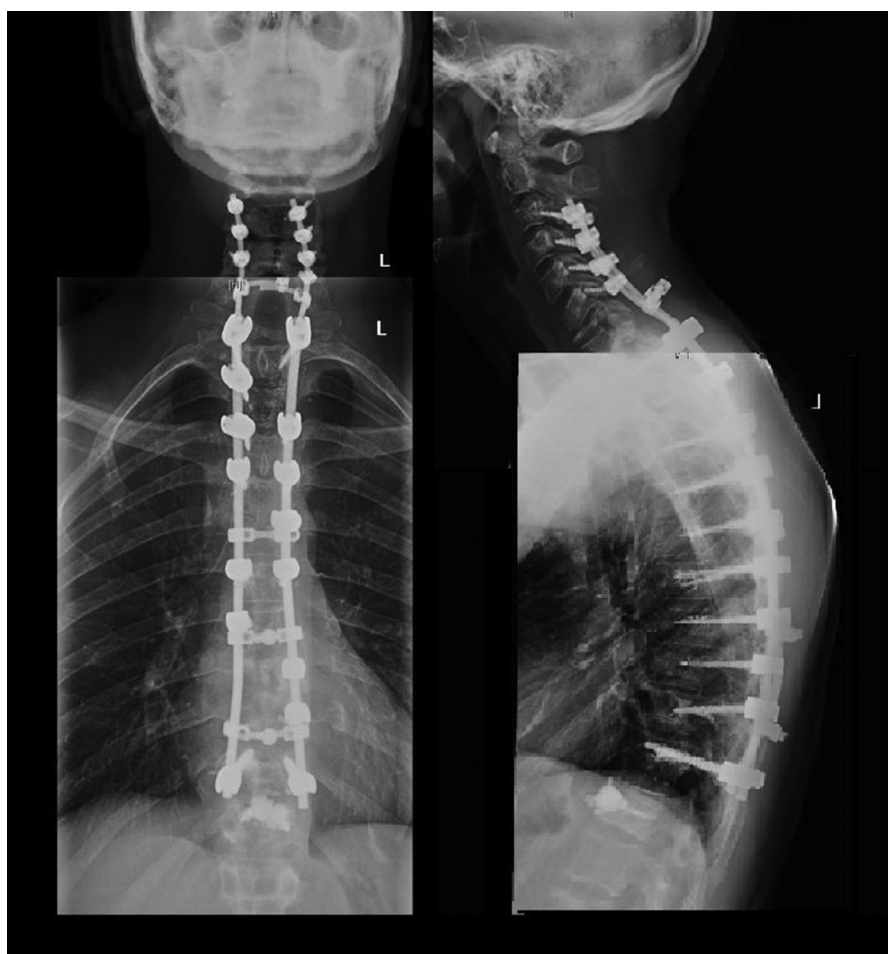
Postoperative coronal (Left) and sagittal (Right) X-rays demonstrating instrumented fusion from C3 to T10 with cement augmented pedicle screws and vertebroplasty at T11 to stabilize the distal portion of the construct.
